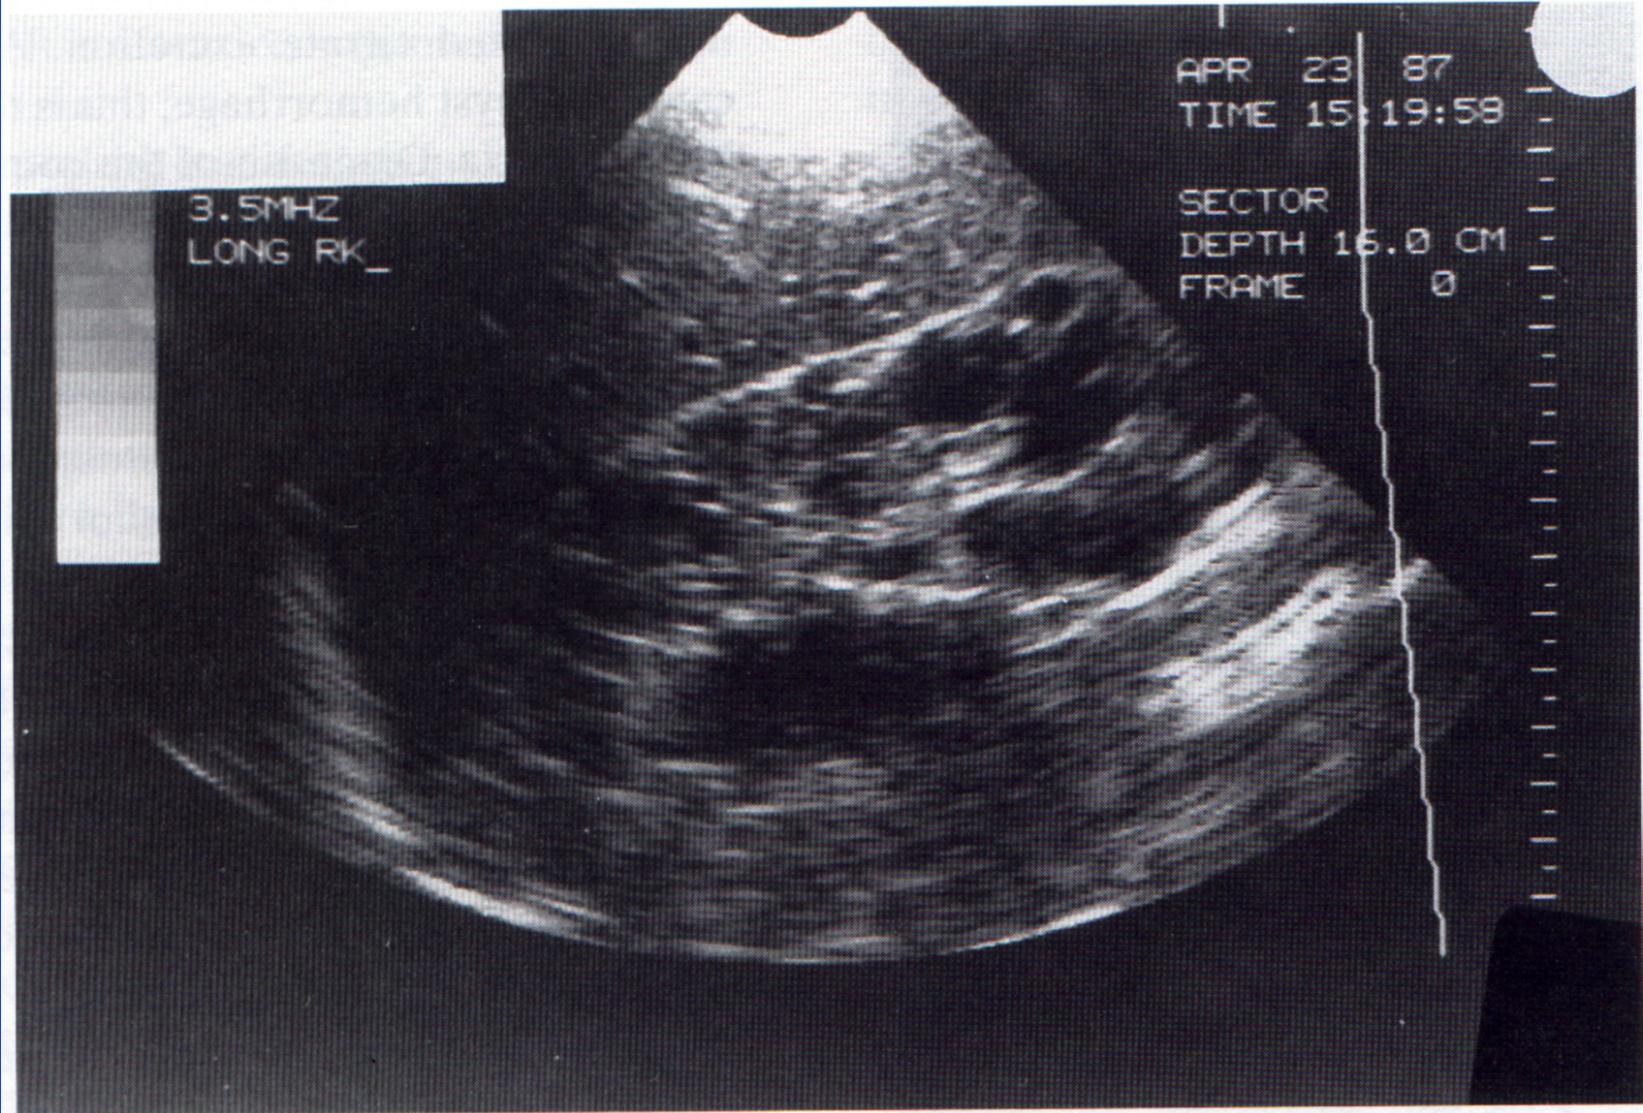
Renal ultrasonogram of a 44-year-old male with autosomal dominant polycystic kidney disease. The kidney is moderately enlarged and contains multiple cysts of variable size.
